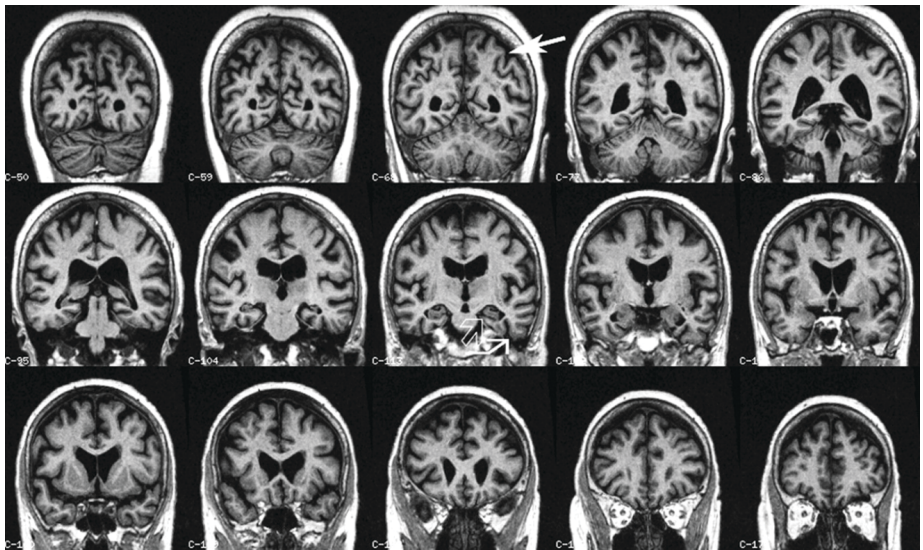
Coronal multiplanar reconstructions of a structural T1-weighted MRI volume. There is slight hippocampal atrophy (open arrow) with concomitant widening of the collateral sulcus (closed kinked arrow), both signs of progressive medial temporal lobe atrophy. We additionally notice slight parietal atrophy (closed arrow), which adds independent predictive value for conversion from mild cognitive impairment to Alzheimer's disease.
